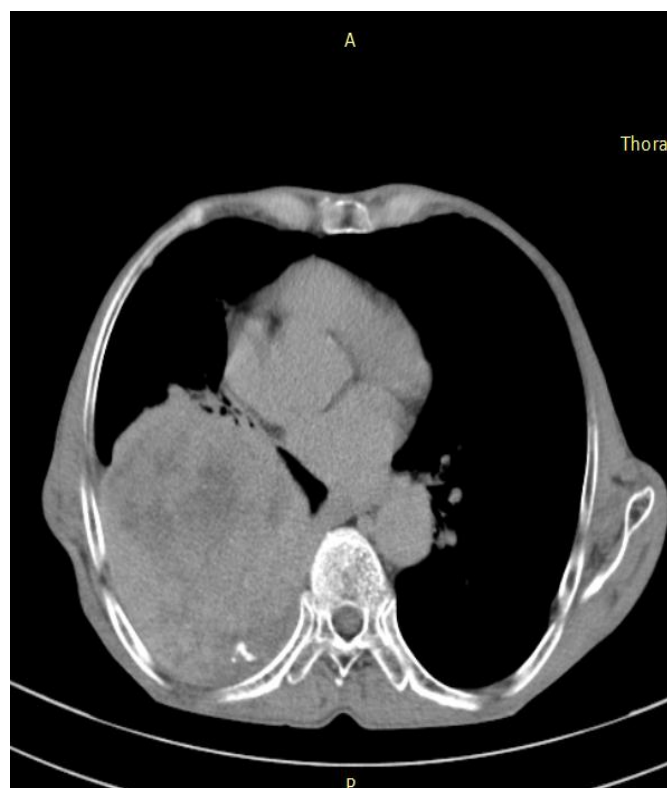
5 minutes delayed post contrast axial CT image showing progressive enhancement rendering the lesion more homogenous.
